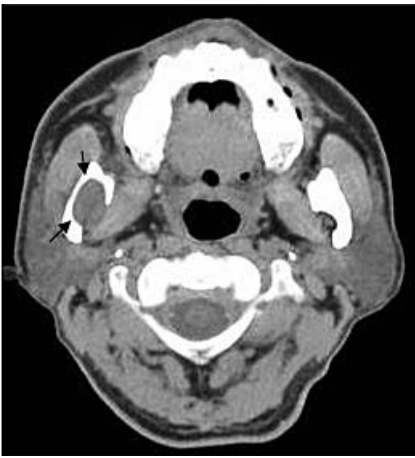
An axial CT scan showing a space-occupying mass with clear borders. Compressive resorption of the mandible can be observed (arrows).
